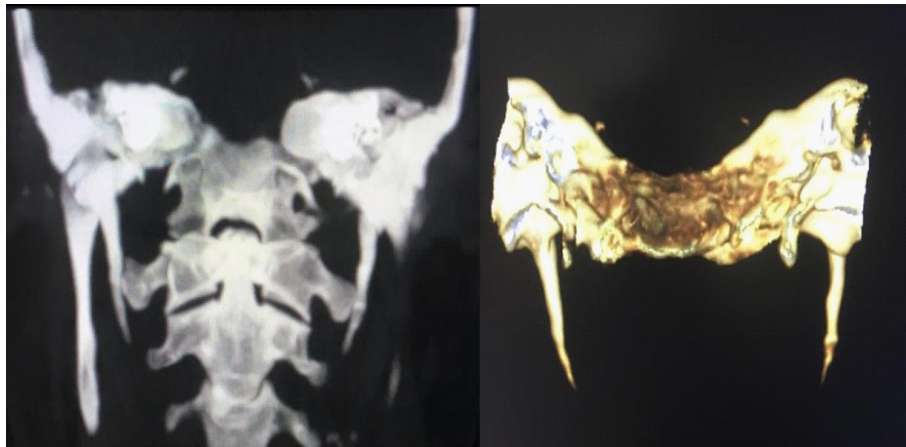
CT reconstructed image showing abnormally elongated styloid process Rt side: 37mm, Left side 39 mm (Normal: 25mm).
